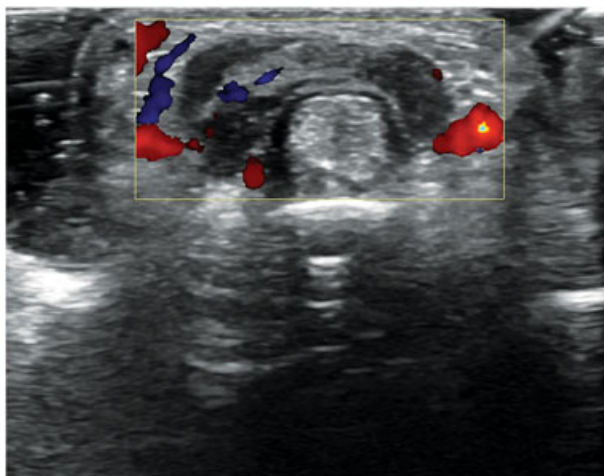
Transverse B-mode and Colour Doppler images shows the hypoechoic, heterogeneous, solid mass encasing the flexor tendons.
